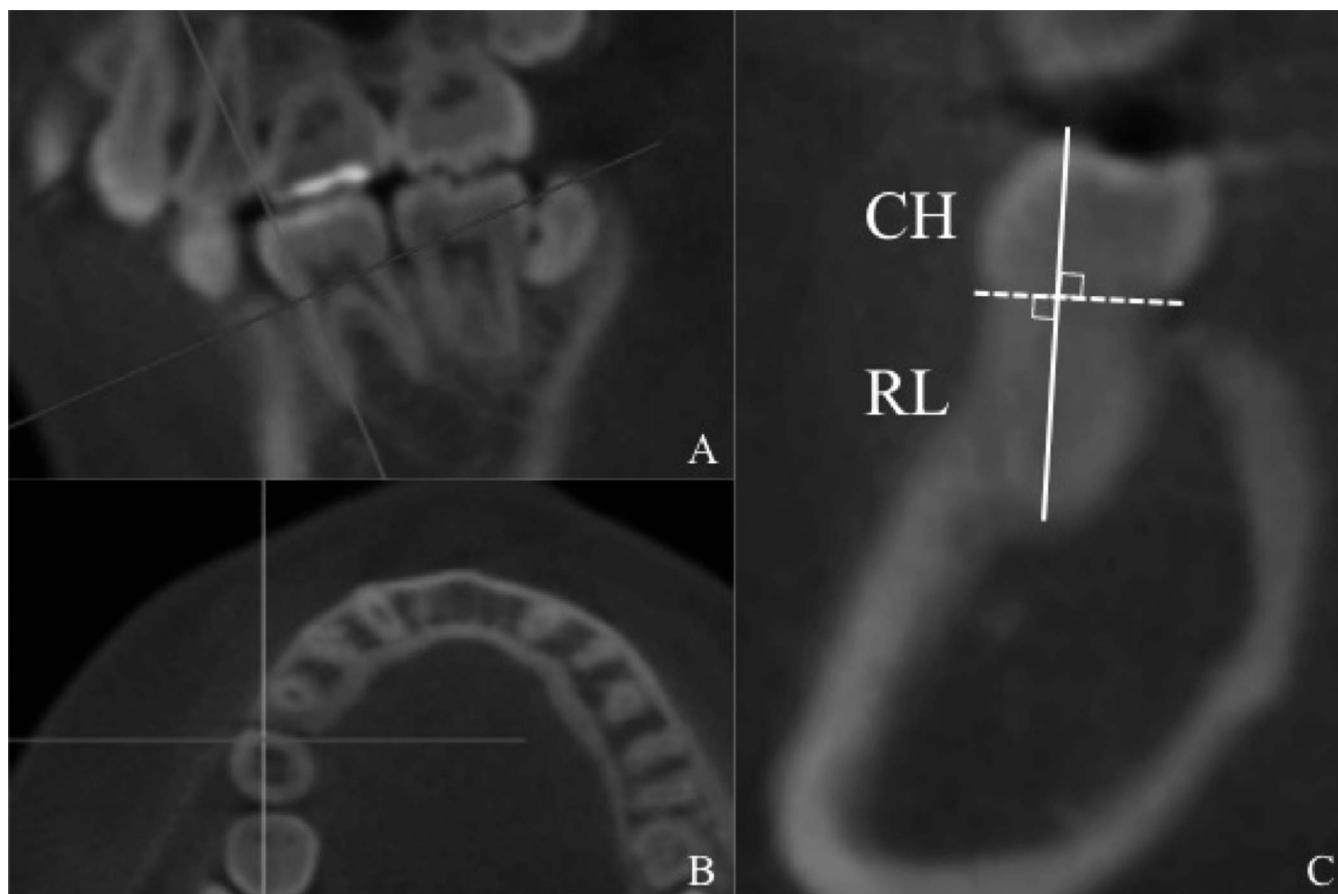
Tooth size measurements performed using CBCT images: (A) sagittal plane; (B) axial plane; and (C) coronal plane. Tooth size was measured in the coronal plane (CH indicates crown height; RL, root length).
